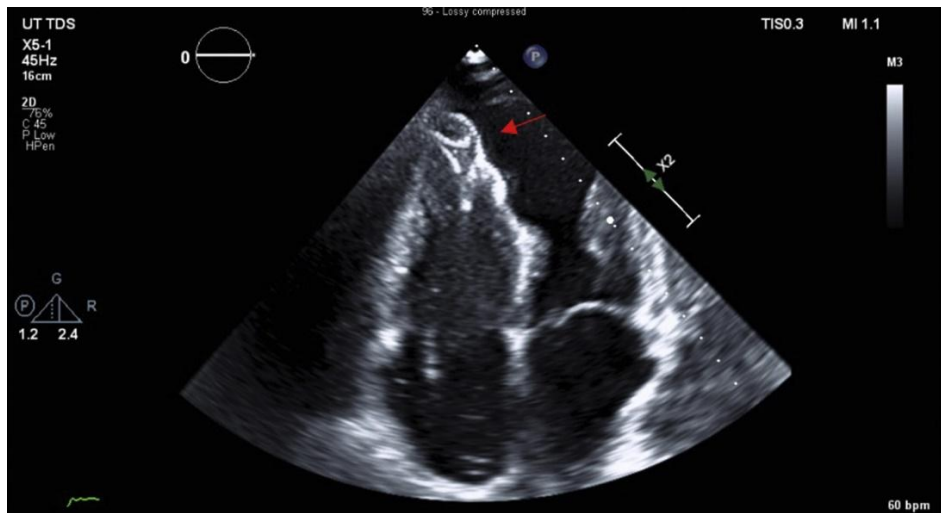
Echocardiogram for acute coronary syndrome [27]
